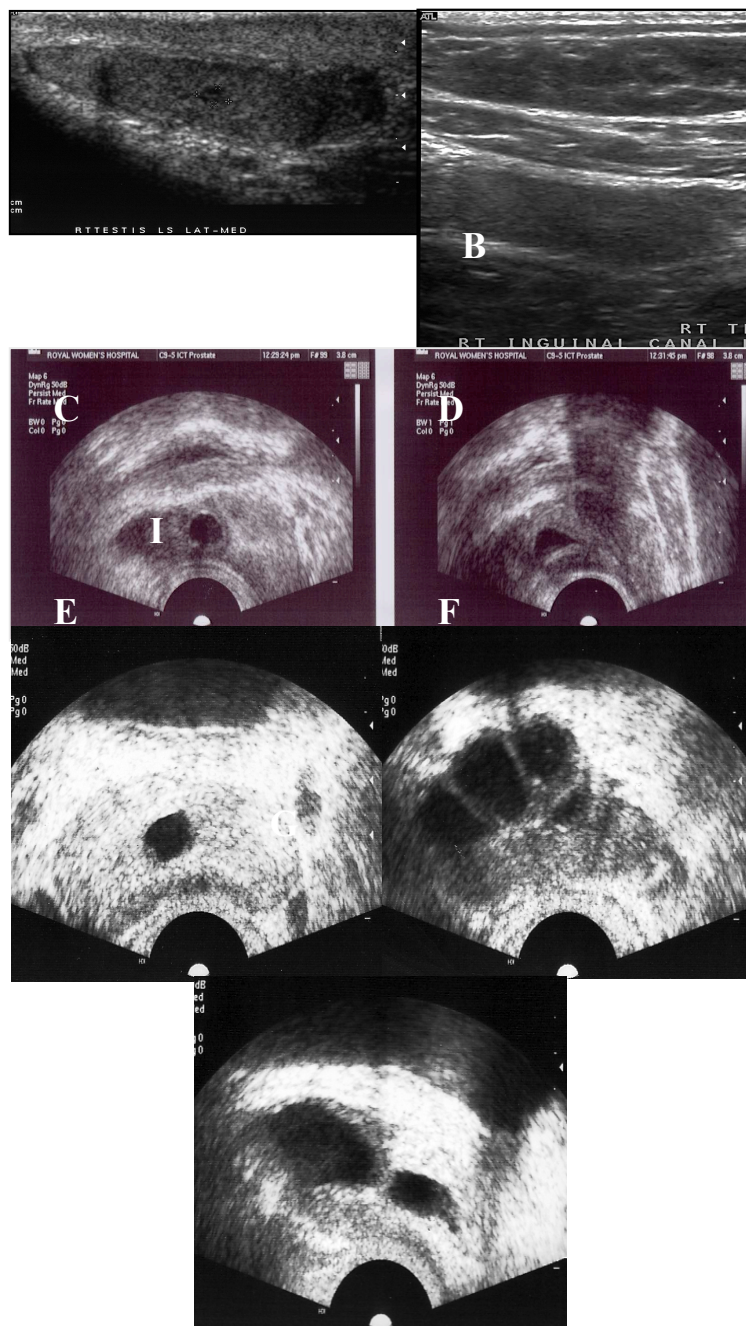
Ultrasound of undescended testes. A - In neck of scrotum at external inguinal ring with small tumour; B - In inguinal canal; Incidental prostatic cyst in a healthy man: C - transverse, D - sagittal; Ejaculatory duct obstruction: E - prostate transverse - dilated ejaculatory duct; F - transverse, dilated seminal vesicle; G - sagittal, dilated duct and seminal vesicle.
